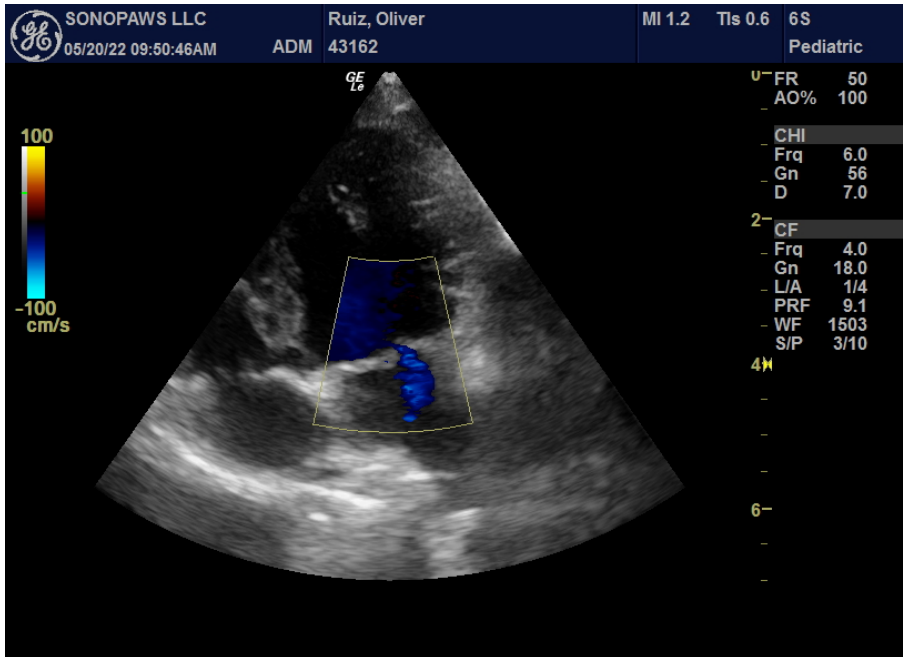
Left apical 4-chamber view. Color doppler on the mitral valve demonstrating mild MR.
